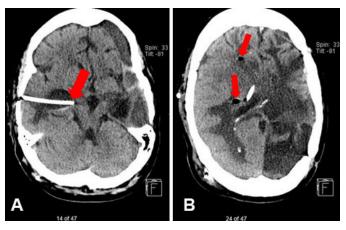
(A) Head CT showing a new shunt catheter was placed through the right temporal bone and extended into the temporal horn of the right lateral ventricle for decompression. (B) There were small amounts of gas and blood within the temporal horn. The right-sided frontal ventricular shunt is still present.
